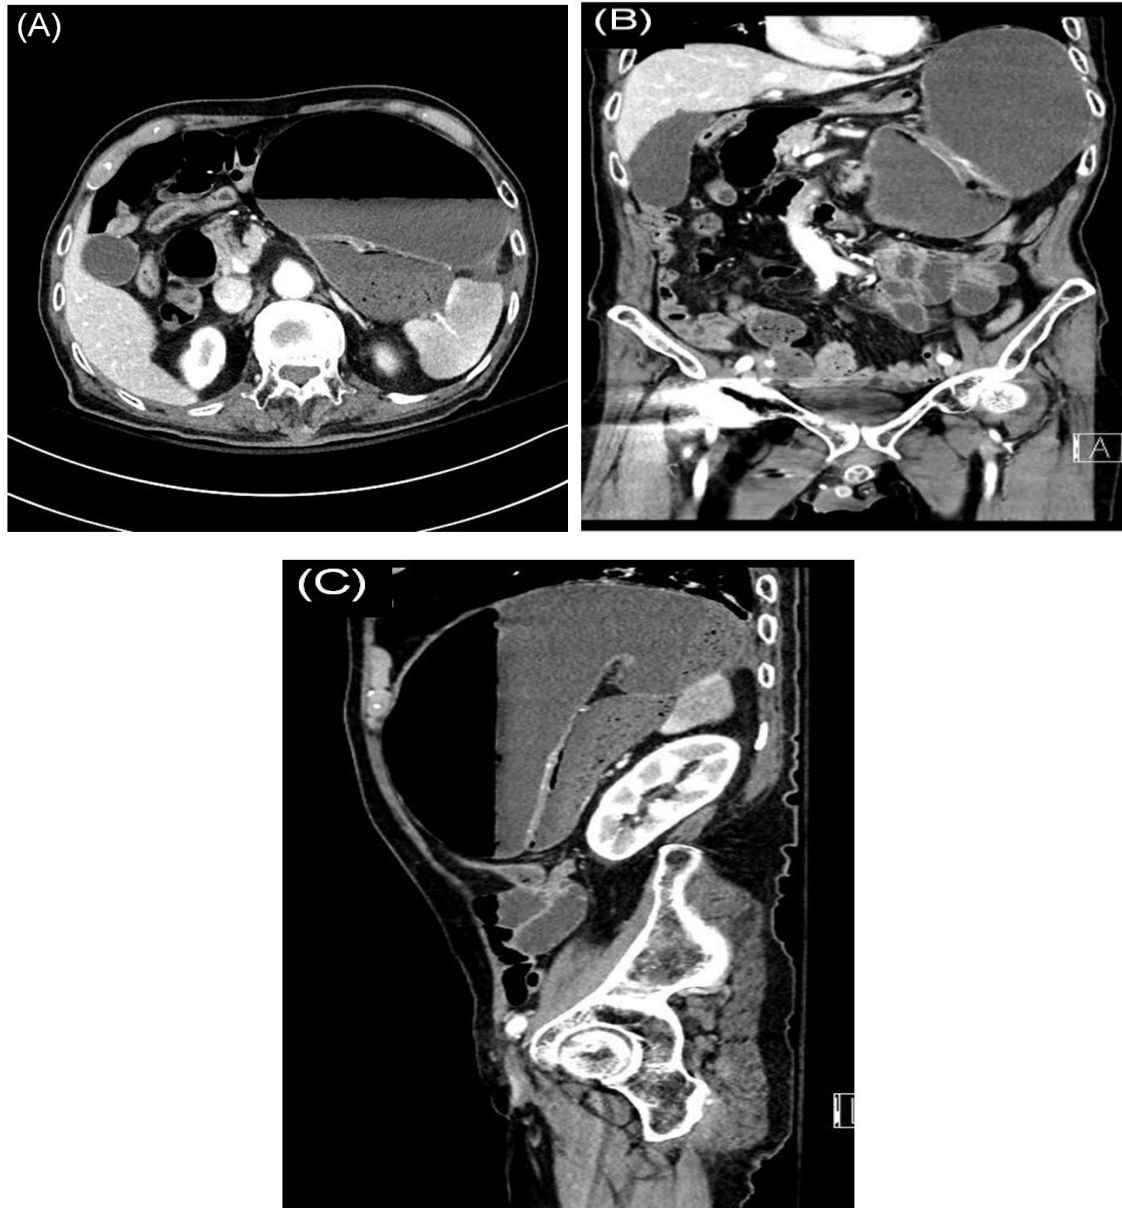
Axial (A), coronal (B), sagittal (C) abdominopelvic CT scans demonstrating obstructive fluid filled gastric dilatation with gastric volvulus.
